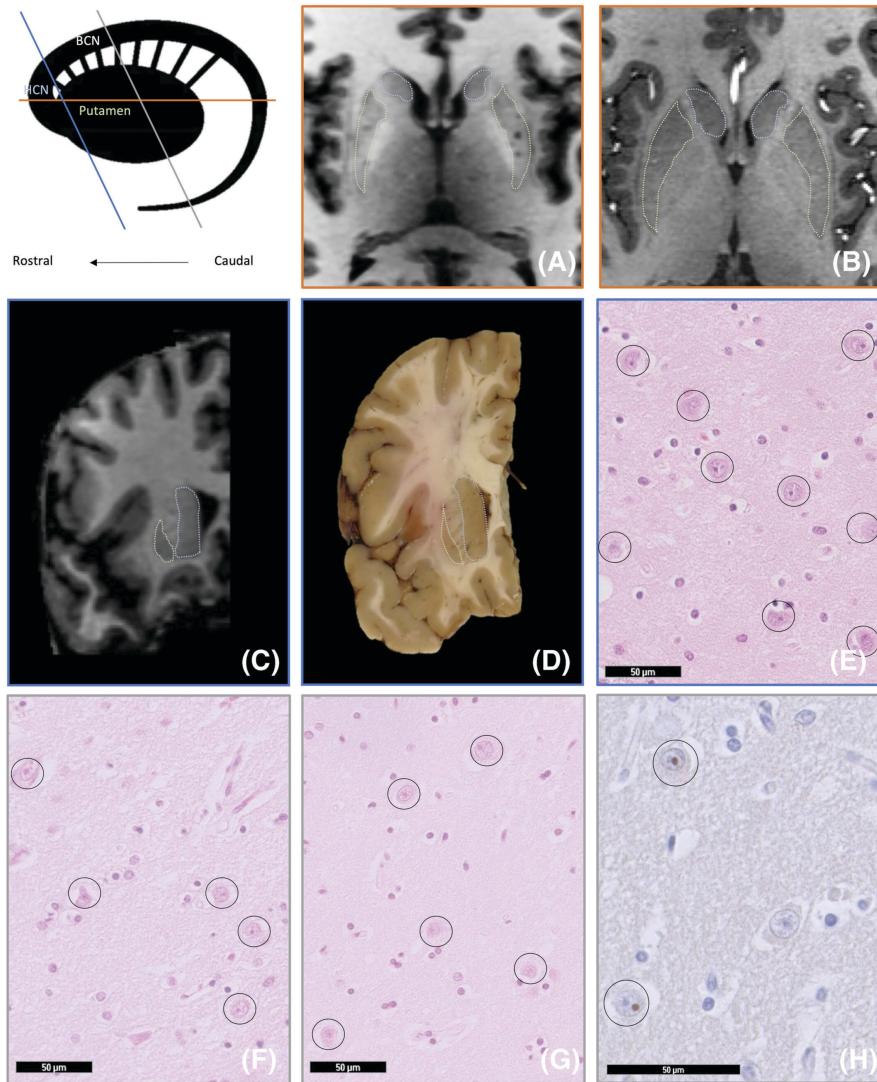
Postmortem 7T MRI imaging and neuropathology of a juvenile-onset Huntington disease (HD) brain donor.
